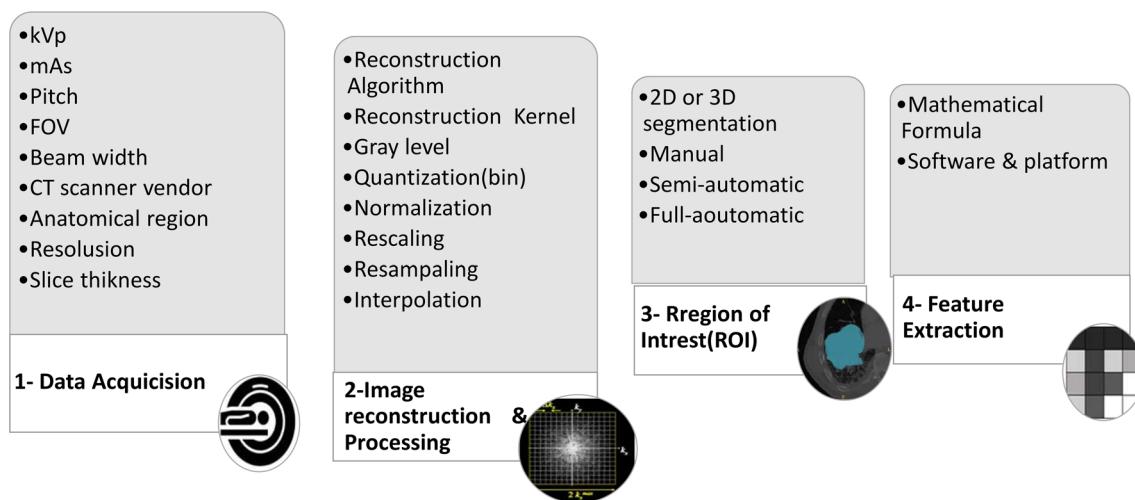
Classification of different CT scanning parameters affecting radiomics
